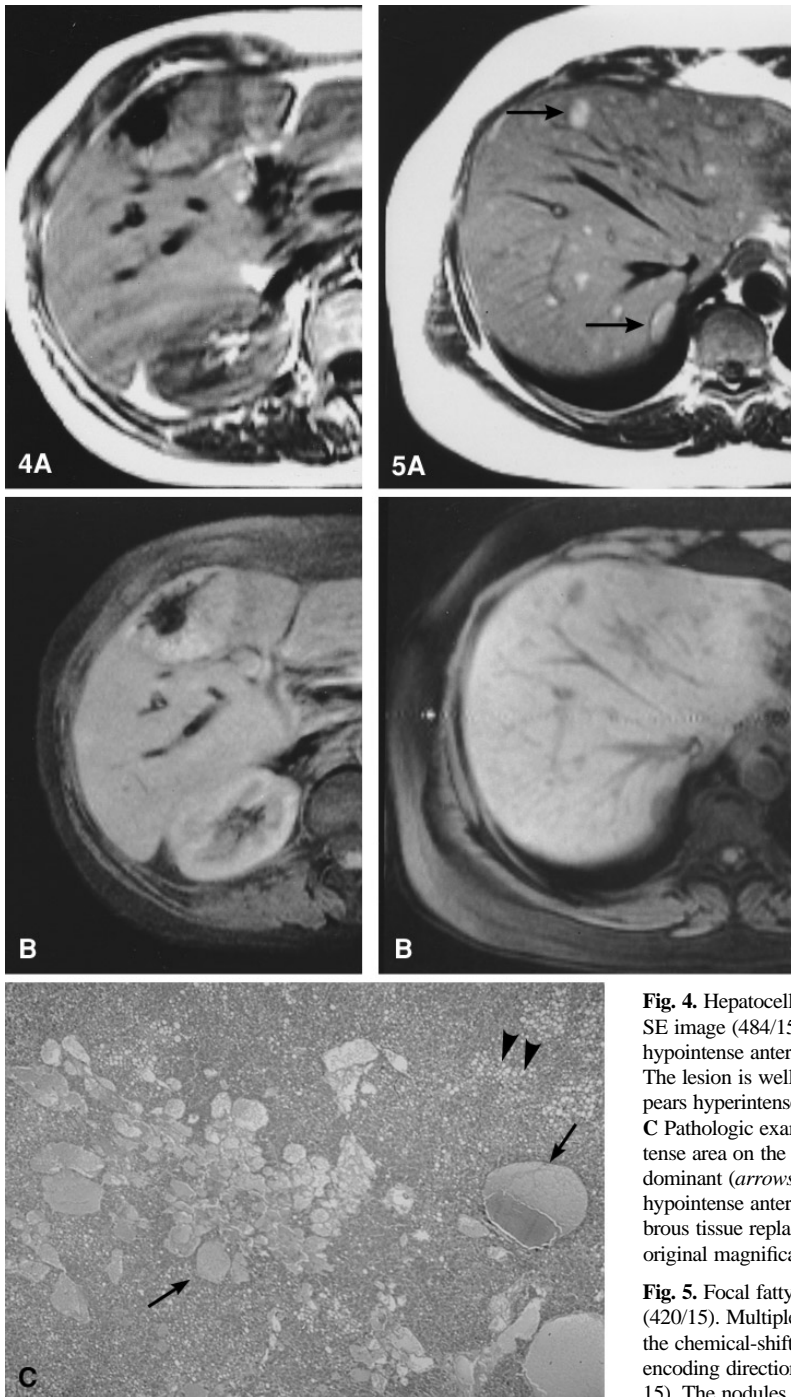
Hepatocellular adenoma with sinusoidal dilatation. A T1-weighted SE image (484/15). The lesion is hyperintense relative to the liver, with a hypointense anterior area. B Fat-suppressed T1-weighted images (484/15). The lesion is well demarcated from the surrounding parenchyma and appears hyperintense relative to the liver, with a hypointense anterior area. C Pathologic examination of the resected tumor. In the posterior hyperintense area on the T1-weighted SE image, a sinusoidal dilatation was predominant (arrows), combined with fatty deposition (arrowheads). The hypointense anterior area on SE T1-weighted images corresponded to a fibrous tissue replacing the previous hemorrhage (hematein-eosin-safran; original magnification, $\times 32$).
